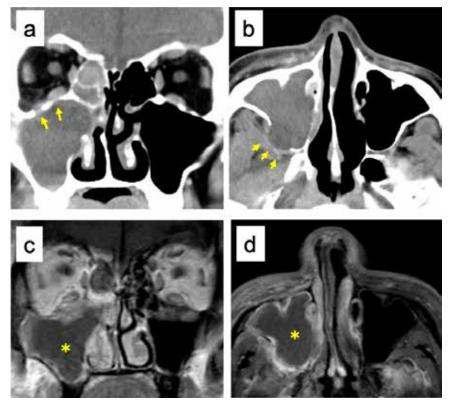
Initial computed tomography reveals a right maxillary sinus shadow with moth-eaten pattern of bone destruction (a, b; yellow arrows).
